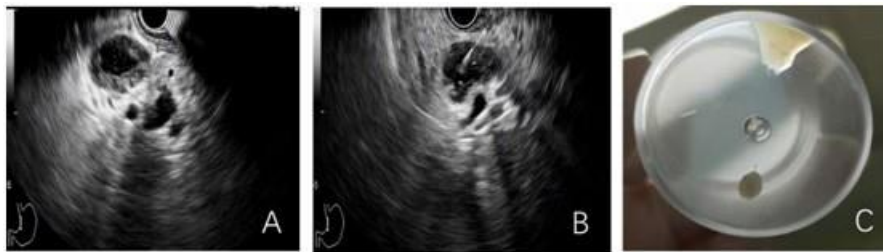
Endoscopic ultrasonography and fine needle aspiration (EUS-FNA) of the enlarged and necrotic lymph nodes.
